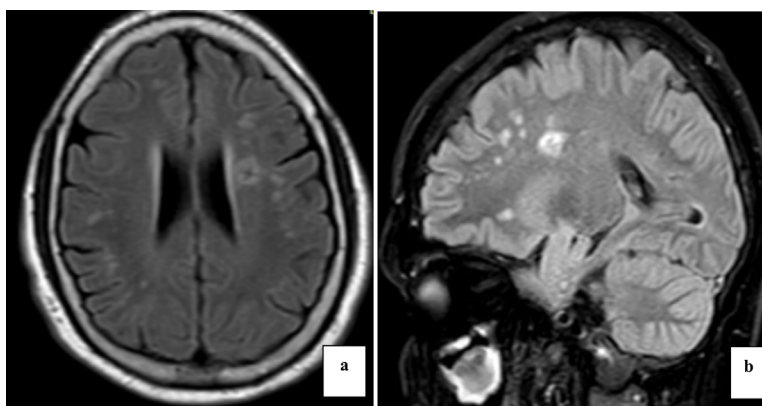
A Diagnosis of Multiple Sclerosis was Established in the Same Patient. MRI Brain (a) Axial and (b) Sagittal FLAIR Images Reveal Several Bilateral Periventricular and Subcortical White Matter Lesions and foci of Elevated Signal, with the Most Prominent Located in the Left Frontal Area, Exhibiting Central Hypointensity.
